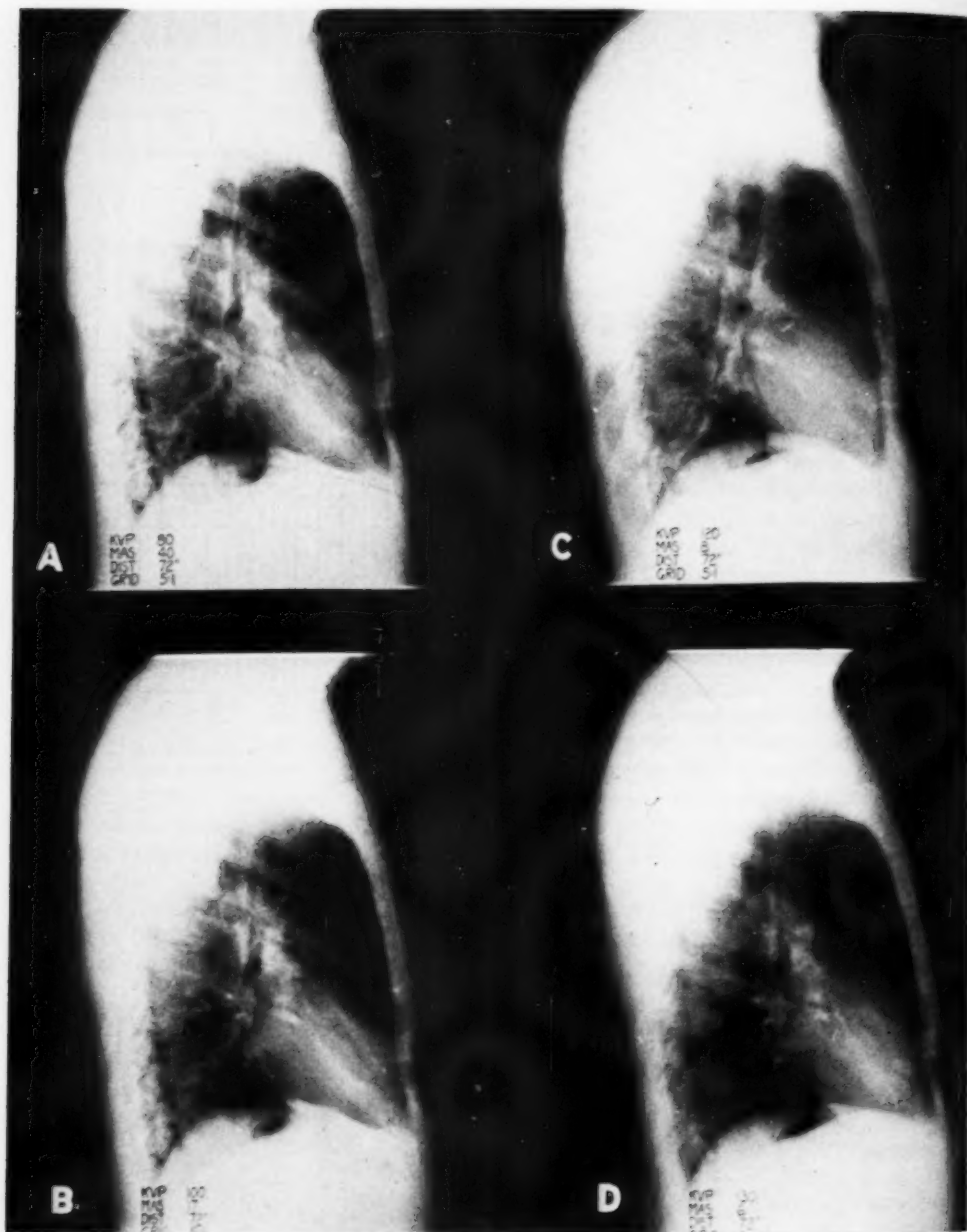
Lateral radiographs of chest. A. 80 kv.p., 40 ma., 72 in. distance, 5:1 grid. B. 100 kv.p., 17 ma., 72 in. distance, 5:1 grid. C. 120 kv.p., 8 ma., 72 in. distance, 5:1 grid. D. 130 kv.p., 6 ma., 72 in. distance, 5:1 grid.
